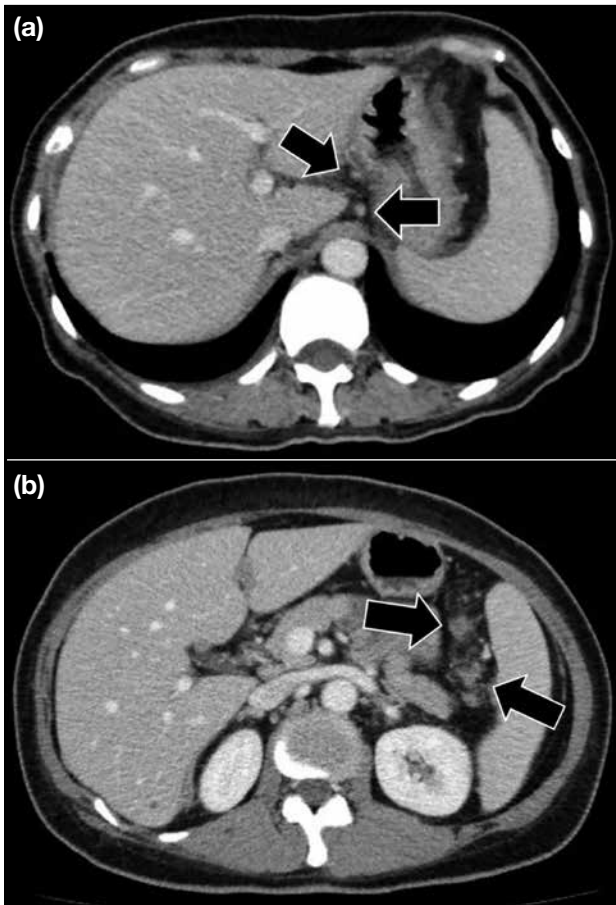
Contrast computed tomography images demonstrating peritoneal deposits at the upper abdominal ligaments, where (a) shows nodular deposits at the gastrohepatic ligament (arrows) and (b) shows nodular deposits at the gastrosplenic ligament (arrows).
